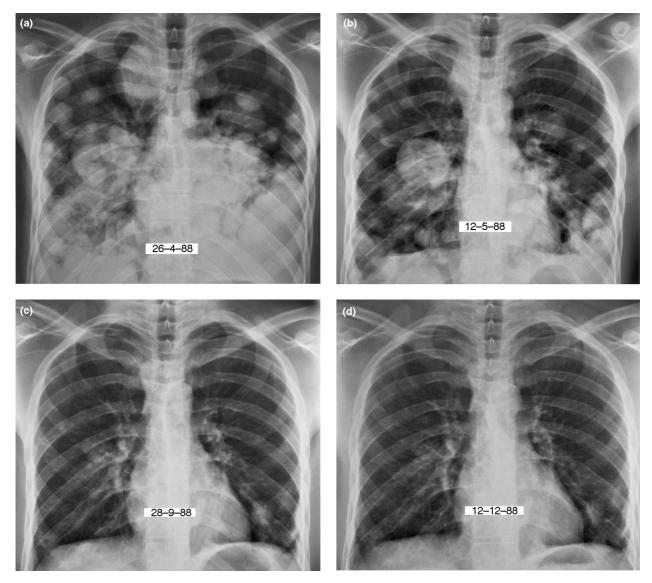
Metastatic synovial sarcoma. (a) Baseline chest X-ray. (b) Partial remission with CyADIC. (c) Maximum response with CyADIC. (d) Further partial response with ifosfamide.
